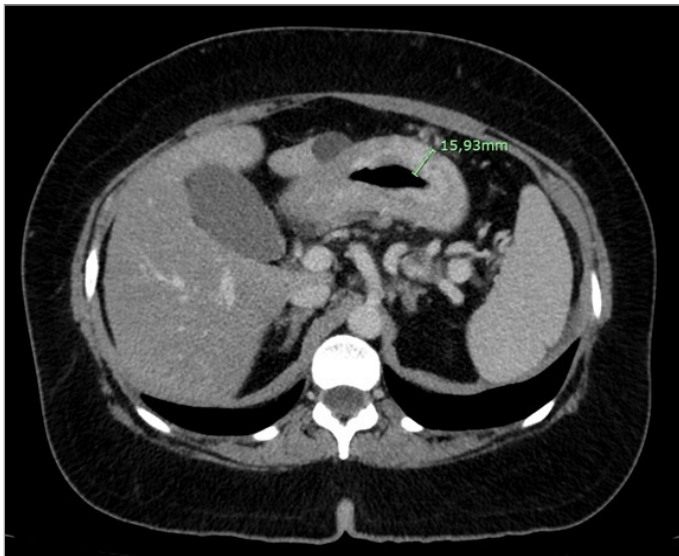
CT scan demonstrates pangastric wall thickening compatible with gastric linitis plastica
